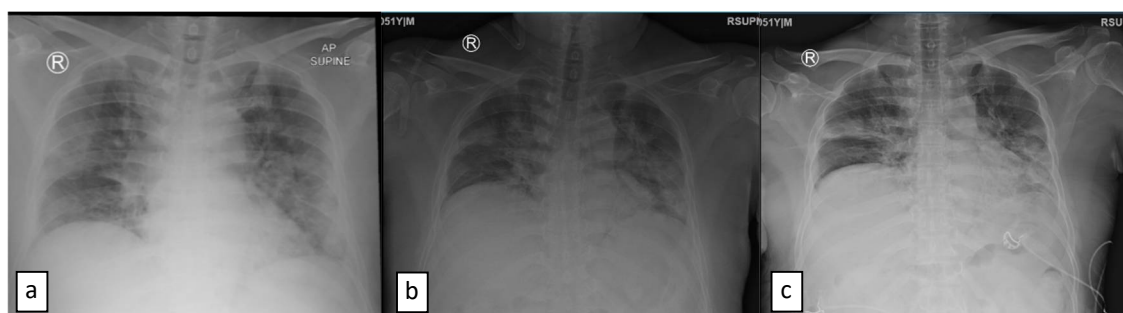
Serial Chest X-ray on: (a) Day 1; (b) Day 6; and (c) Day 21 of Hospitalization of Patient 2.
